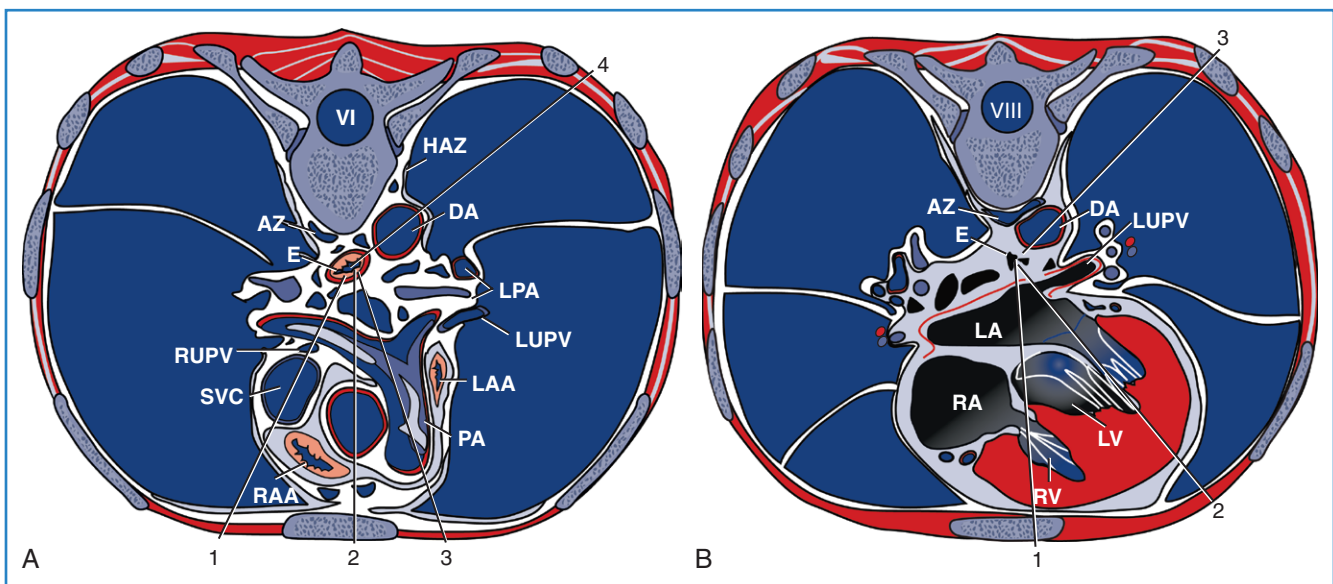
Transesophageal echocardiogram. Transverse sections. A and B, Sections obtained at the level of the sixth (A) and eighth (B) vertebrae. AZ, Azygos; DA, descending thoracic aorta; E, esophagus; HAZ, hemiazygos vein; LA, left atrium; LAA, left atrial appendage; LPA, left pulmonary artery; LUPV, left upper pulmonary vein; LV, left ventricle; PA, main pulmonary artery; RA, right atrium; RAA, right atrial appendage; RUPV, right upper pulmonary vein; RV, right ventricle; SVC, superior vena cava. (From Nanda NC, Pinheiro L, Sanyal RS, et al: *Transesophageal biplane echocardiographic imaging: Technique, planes, and clinical usefulness*, Echocardiography 7:771–788, 1990.)
